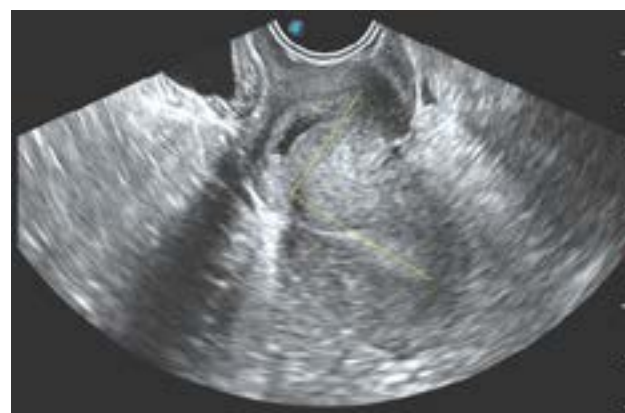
Woman with anteverted retroflexed uterus. Ultrasound image shows cervix angled anteriorly and fundus is angled posteriorly and is at right-angle axis to cervix. Yellow lines show the flexion angle measurement between the uterine cervix and uterine corpus (279.9)
